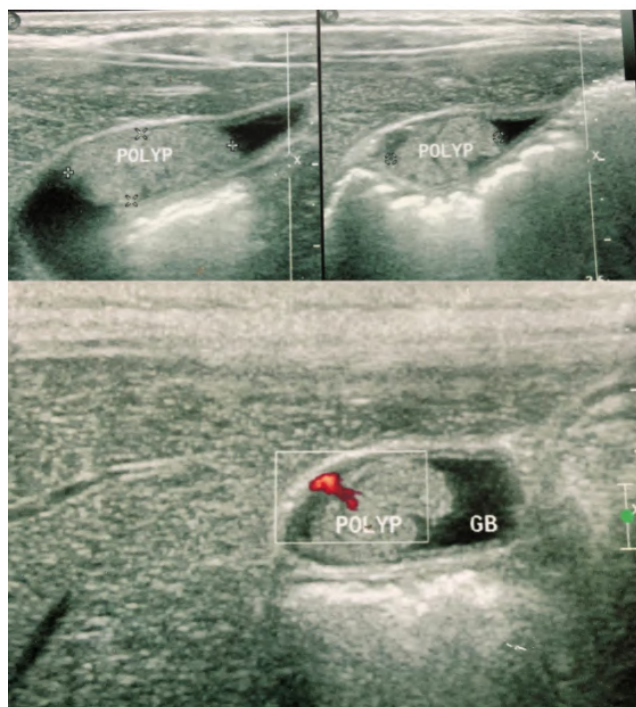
Ultrasonography showing gall bladder polyp with vascular pedicle
